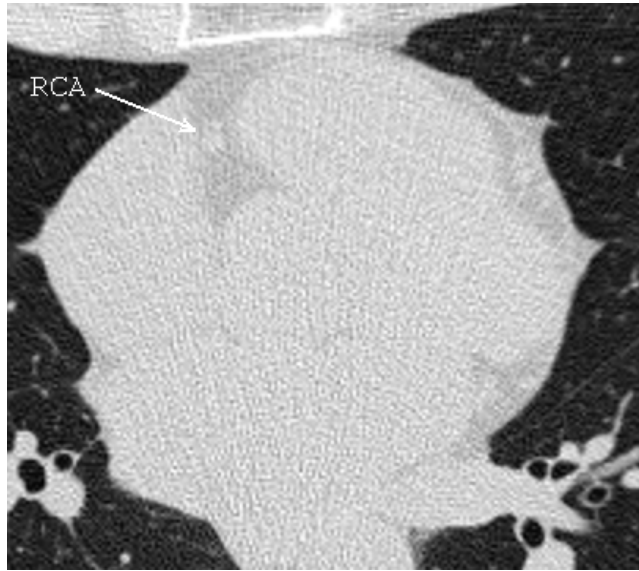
Axial slice of a conventional low-dose CT image: profiles of coronary arteries are barely distinguishable from the surrounding tissue. The arrow shows the only profile of right coronary artery that can be recognized.
